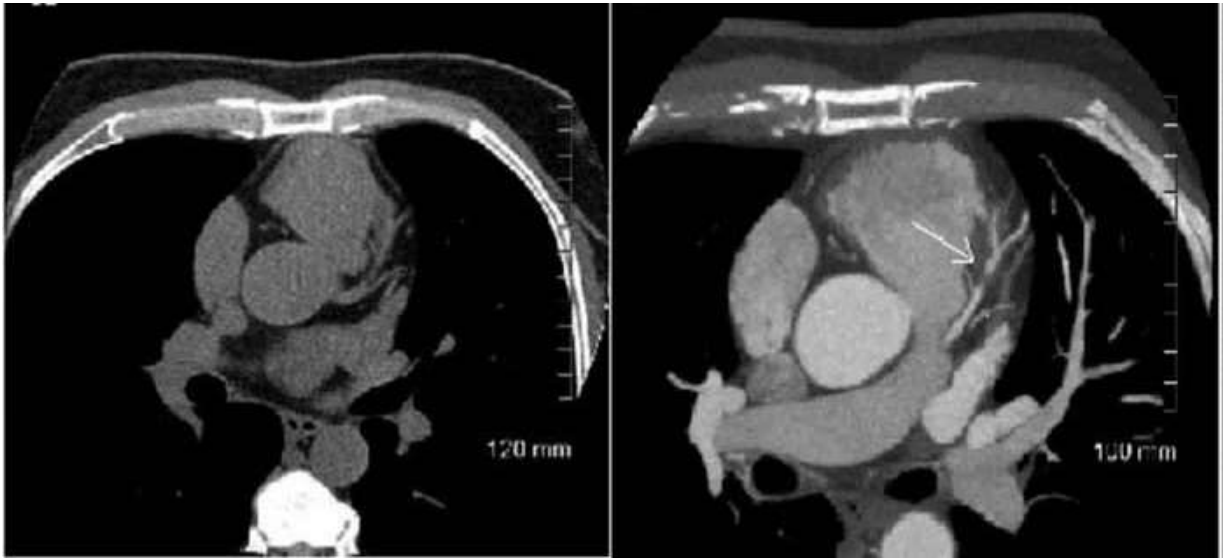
shows axial contrast CT demonstrating the left coronary artery with a stenosis (white arrow) for male patient 68 years.
